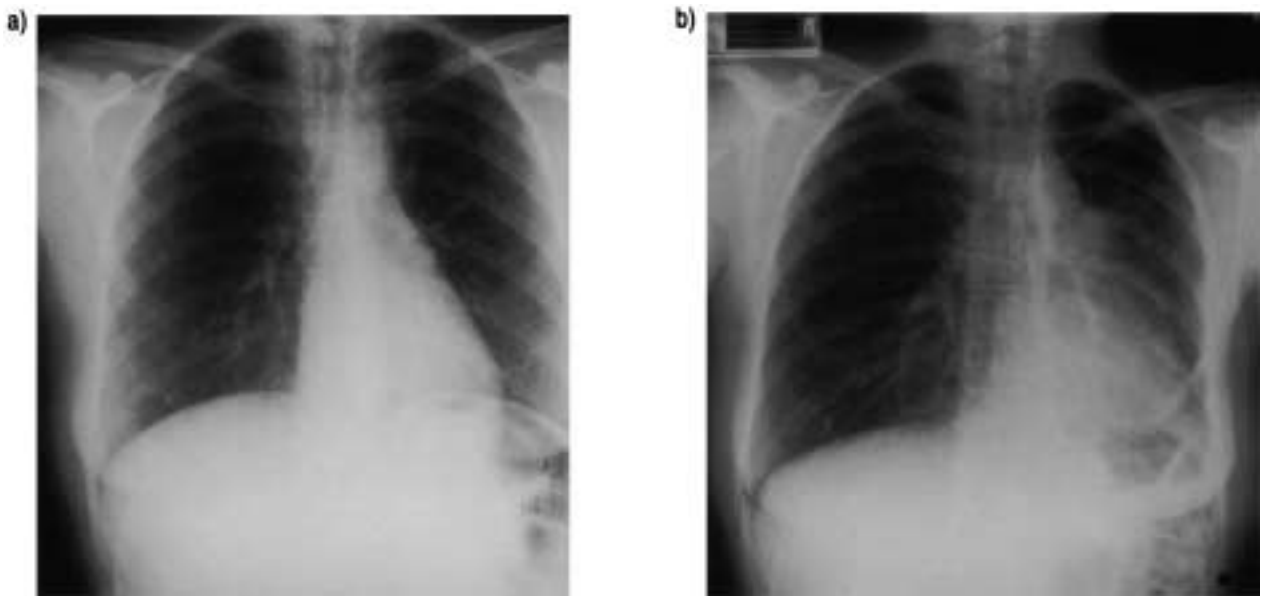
Chest radiography from the donor: a) before and b) 12 months after left lower lobectomy.
